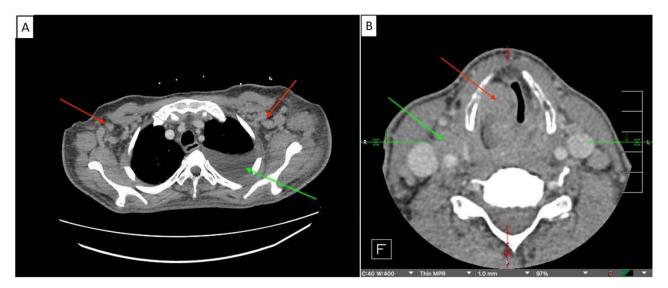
CT chest and abdomen/pelvis with intravenous contrast (A) shows adenopathy, most pronounced in the bilateral axillary regions (red arrows), left side greater than right side, and a moderate left-sided pleural effusion (green arrow). CT larynx/trachea with intravenous contrast (B) shows a 3.6 cm right glottic and supraglottic mass (red arrow) with associated cervical lymphadenopathy (green arrow) bilaterally and mass effect on the airway
